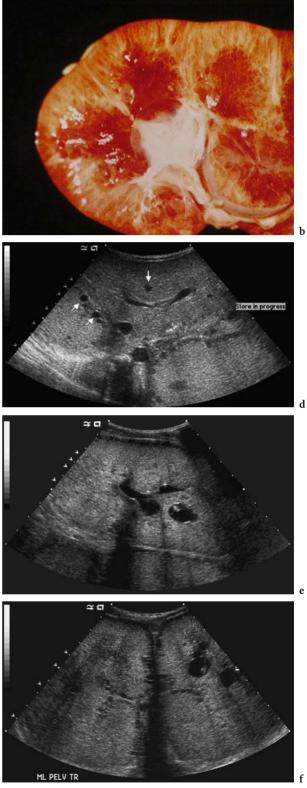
Autosomal recessive polycystic kidney disease (ARPKD). a Pre-natal depiction of ARPKD. b Gross pathology of microcysts in ARPKD. c Hepatomegaly with ascites suggested on neonatal abdominal radiograph with overall deformity suggesting ARPKD. d Echogenic liver with a few cysts (*arrows*). e Longtitudinal left, ftransverse bilaterally midpole. Echogenic, massively enlarged kidneys with "pepper and salt" pattern
